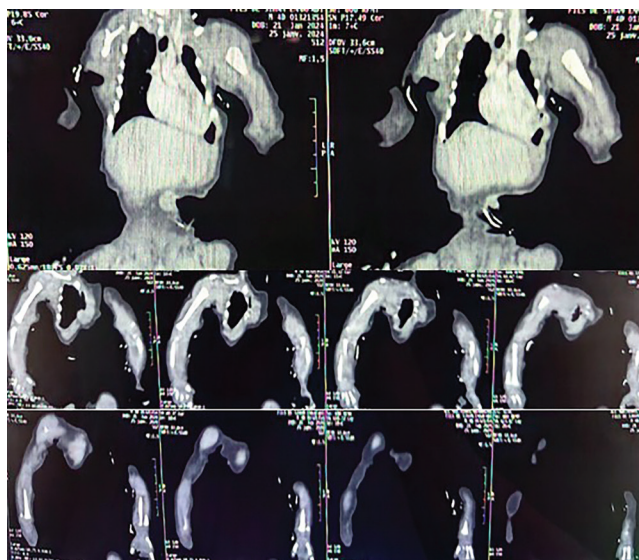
CT angiography images of the upper limbs showing occlusion of the right brachial artery and occlusion of the distal third of the left radial artery
